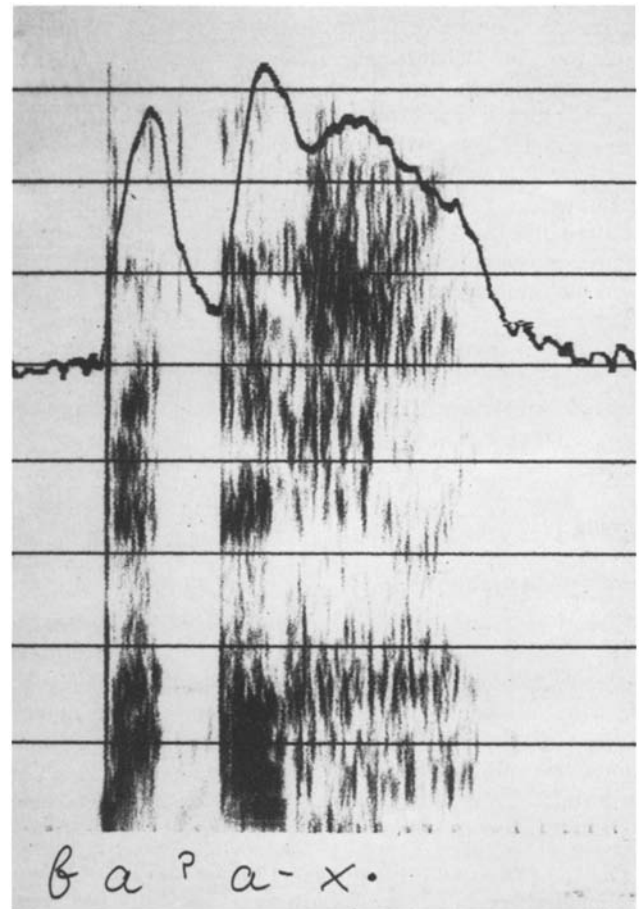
Sonogram of an intraphonemic disruption of 100 ms during the vowel in the word "Bach" (creek). The frequency range on the ordinate is 0 to 8 kHz
